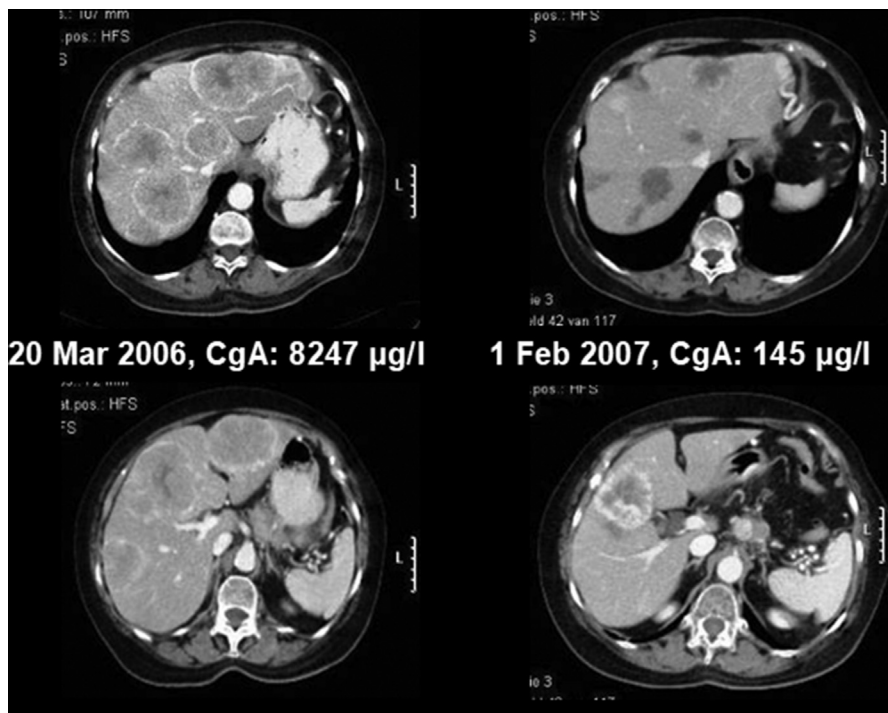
Computed tomography scan of the abdomen showing extensive liver metastases from a neuroendocrine tumor. Impressive tumor response after the administration of a long-acting somatostatin analogue paralleled by a decrease in circulating chromogranin A (CgA) levels.
